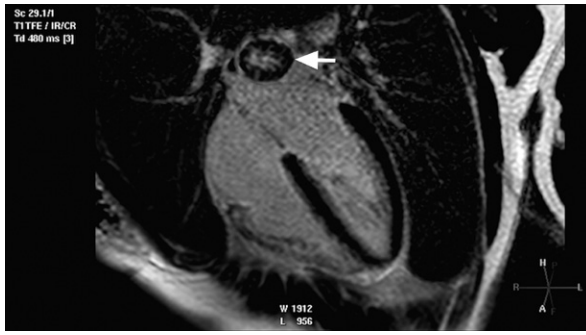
T1-weighted, echo inversion-recovery cardiac magnetic resonance sequence shows a well-demarcated mass (arrow) in the posterior wall of the left atrium.
